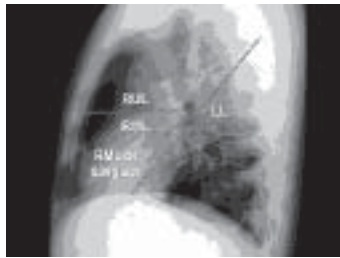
A & B, Normal lung parenchymal and mediastinal structures on Chest PA and Lateral Radiographs
